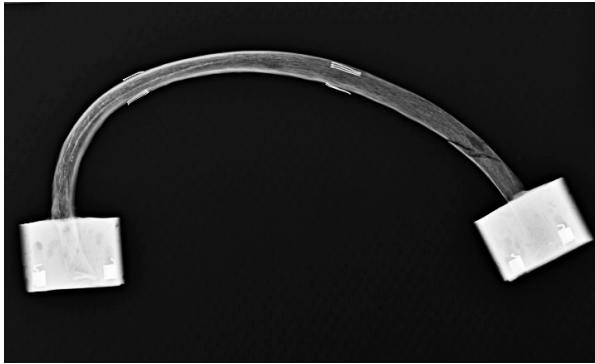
Pair 1 rib (left) and rib+CC (right) post-test x-rays (not to scale)
